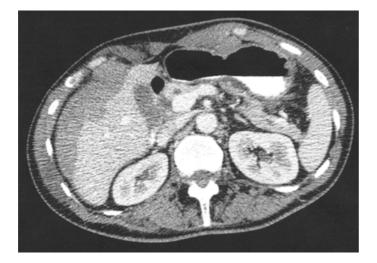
CT of the abdomen/pelvis with intravenous contrast. Note the average density of 60 Hounsfield units for the fluid collection (subcapsular hematoma) by the right lobe of the liver; the liver density is about 80 Hounsfield units whereas the adjacent bile averages 29 Hounsfield units.
